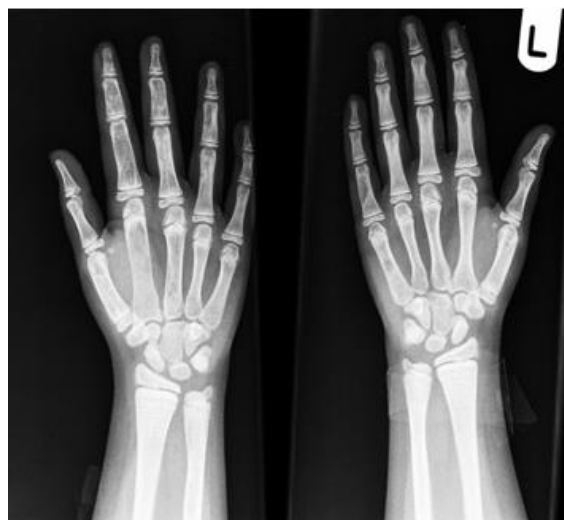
Hand radiograph shows lytic metacarpus and phalanxes.
